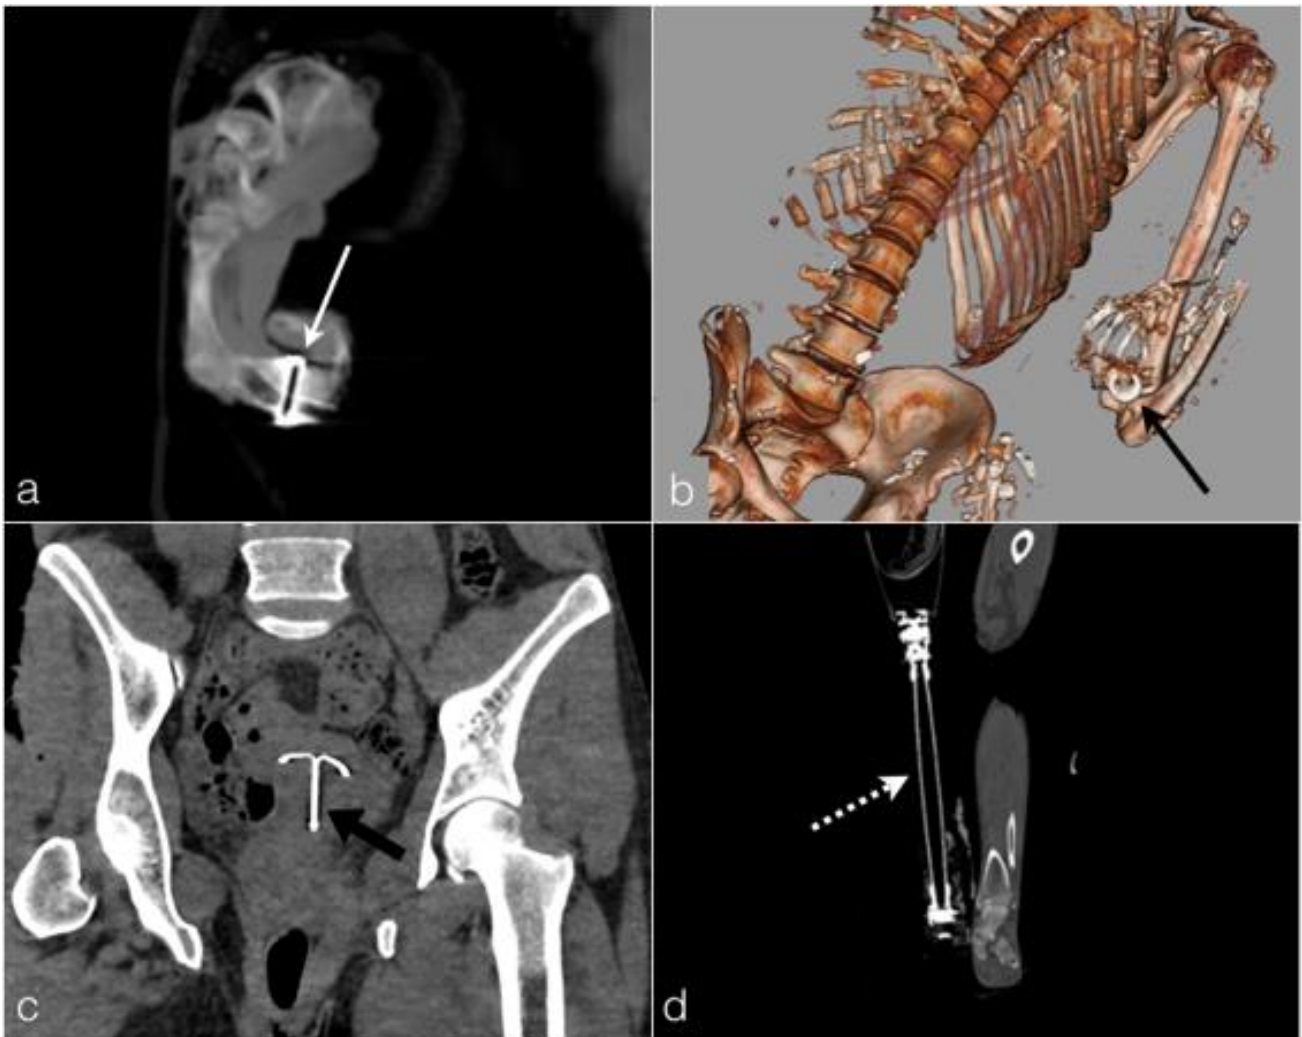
In case of extremely charred body, the foreign bodies viewable on PMCT could help the forensic team to identify the body and should be enumerated in the CT report.
